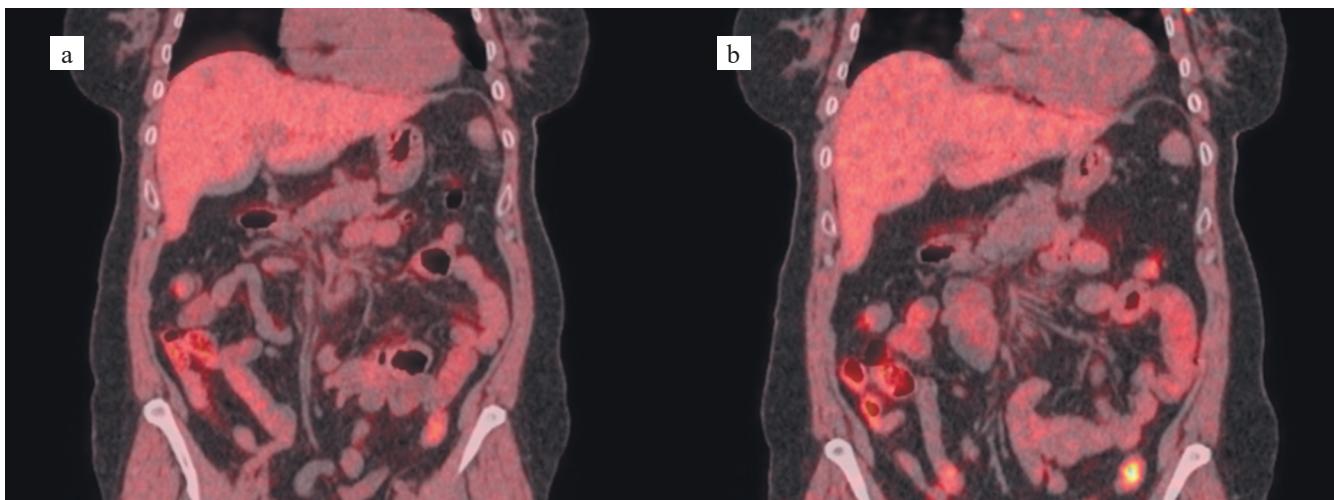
Coronal fused PET/CT images with ^{18}F -FMISO (native CT): (a) at 90 minutes post-injection; (b) at 180 minutes post-injection. Diffuse tracer uptake is evident in the liver, with higher tracer retention relative to background at 180 minutes compared to 90 minutes. Physiological uptake of ^{18}F -FMISO along the colon is also observed
